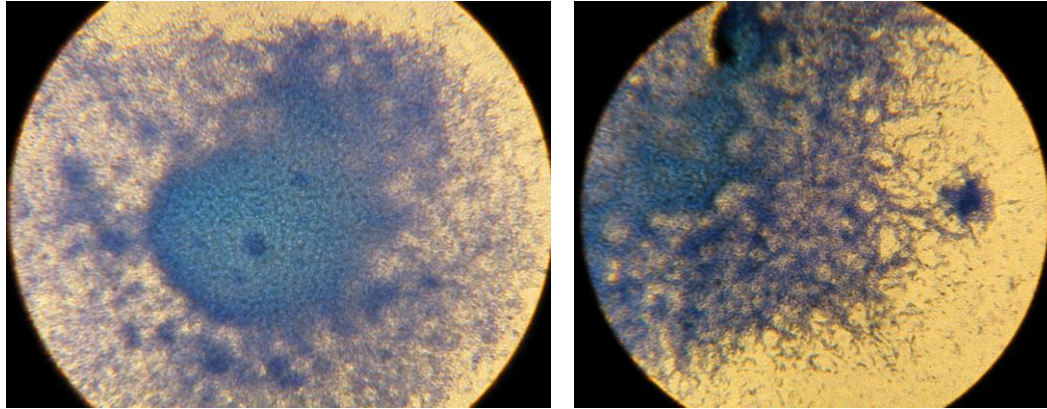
Example of Type III Foci; CTA with BALB/c 3T3 A31-1-1 cells treated with BaP and 3-MCA, respectively, magnification $\times 20$.
